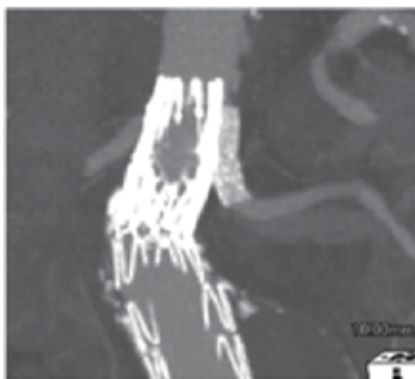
CT showing a snorkel graft.
